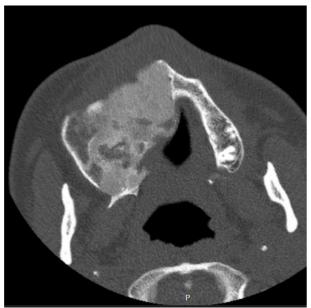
Axial section computed tomography image of the lesion located in the maxilla posterior region.
